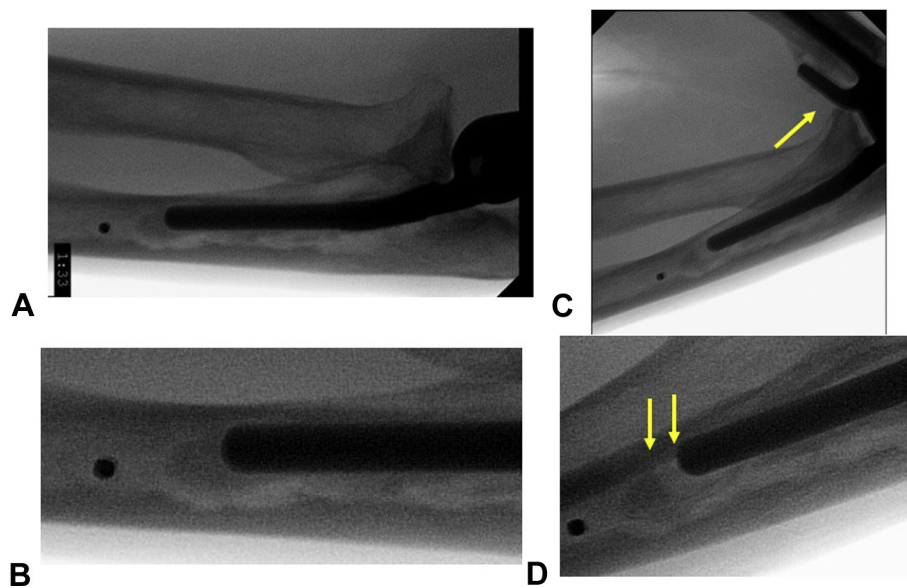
A,B Lateral radiograph of elbow at 30° and 130° flexion. C,D Note the lucency around the ulnar stem. Single arrow shows the coronoid impinging on the humeral flange. Twin arrows show pistoning of the ulnar component with deep flexion.
